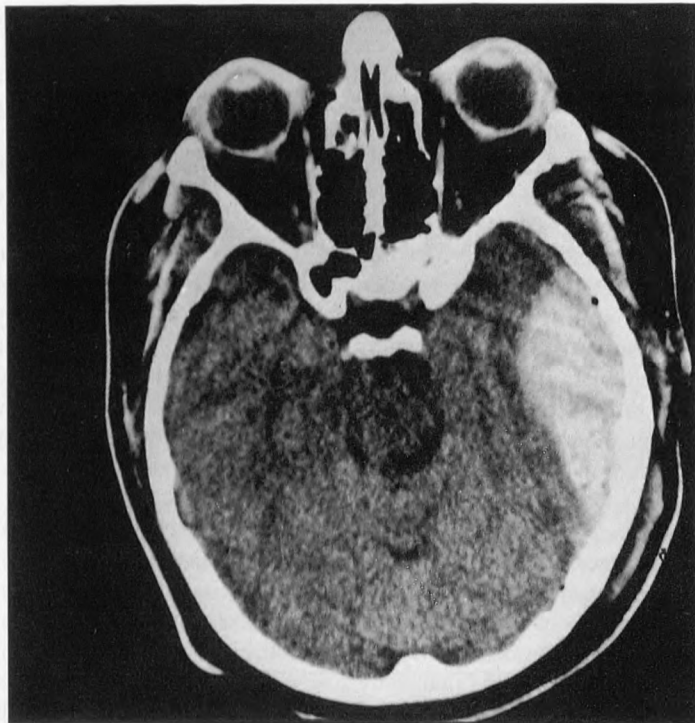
CT scan showing epidural hematoma in the left middle cranial fossa with significant mass effect. The lenticular or biconvex shape is typical, indicative of its extra-axial location.
